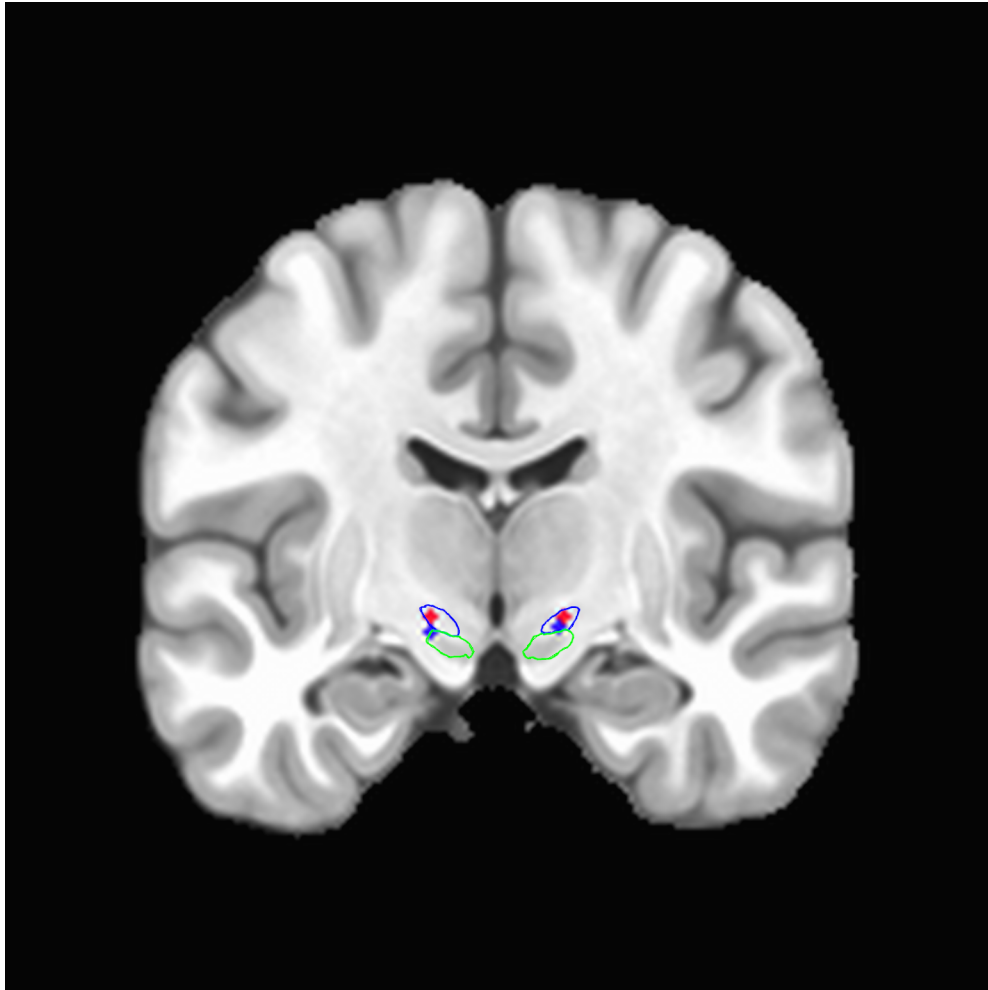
Co-registered aggregate CT scans for visualization of the therapeutic contact (red) and alternate contact (blue) warped to a coronal view of the MNI brain atlas. Subject specific contact locations were aggregated and averaged to represent both locations of stimulation used in our experiments. Outlines in blue and green represent the borders of the subthalamic nucleus and substantia nigra respectively. On average the alternate contact was closest to the substantia nigra whereas the therapeutic was within the subthalamic nucleus.
